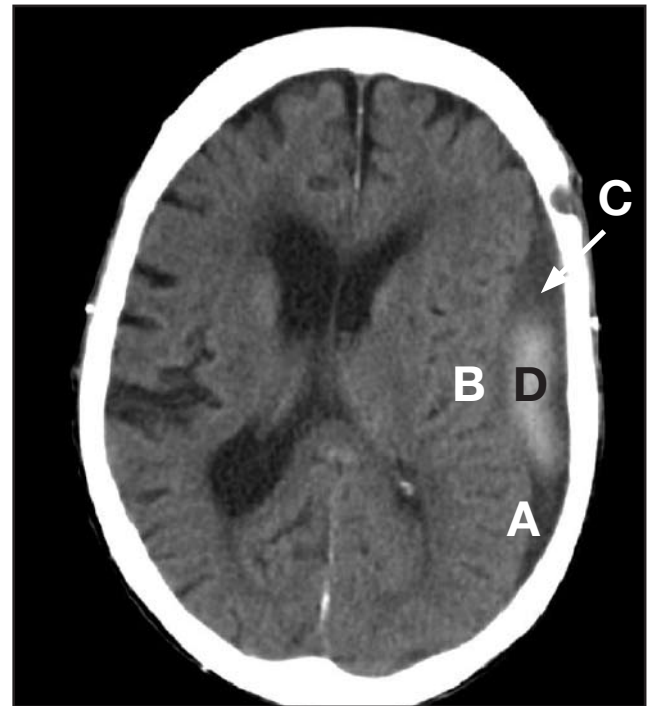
The appearance may be hard to interpret. This CT scan shows a haematoma that has an inner border that is both concave (A) and convex (B) towards the brain in different areas. This CT shows an old subdural (the old blood is dark on the CT rather than white - C), but there has been a recent rebleed of fresh blood into the haematoma (D).
